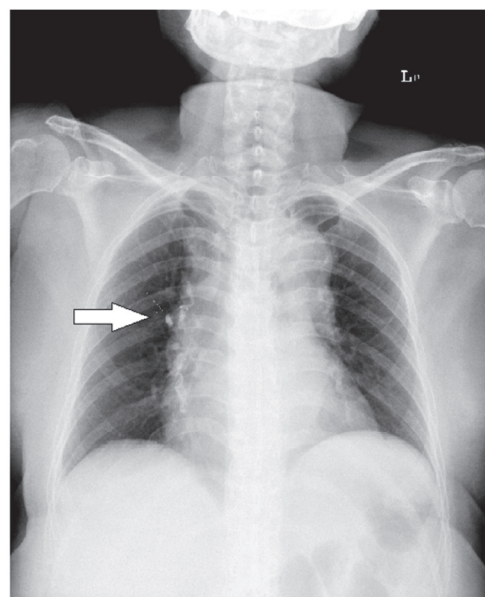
Anteroposterior view of chest x-ray (CXR) revealed multiple radiopaque materials within the right pulmonary trunk.
